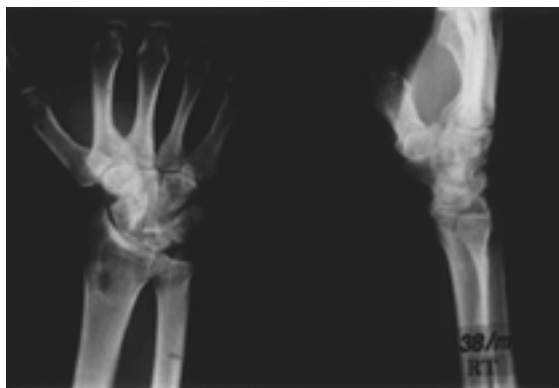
Anteroposterior and lateral view of wrist at 26 months after scaphocapitate fusion. Radiograph show good union.
